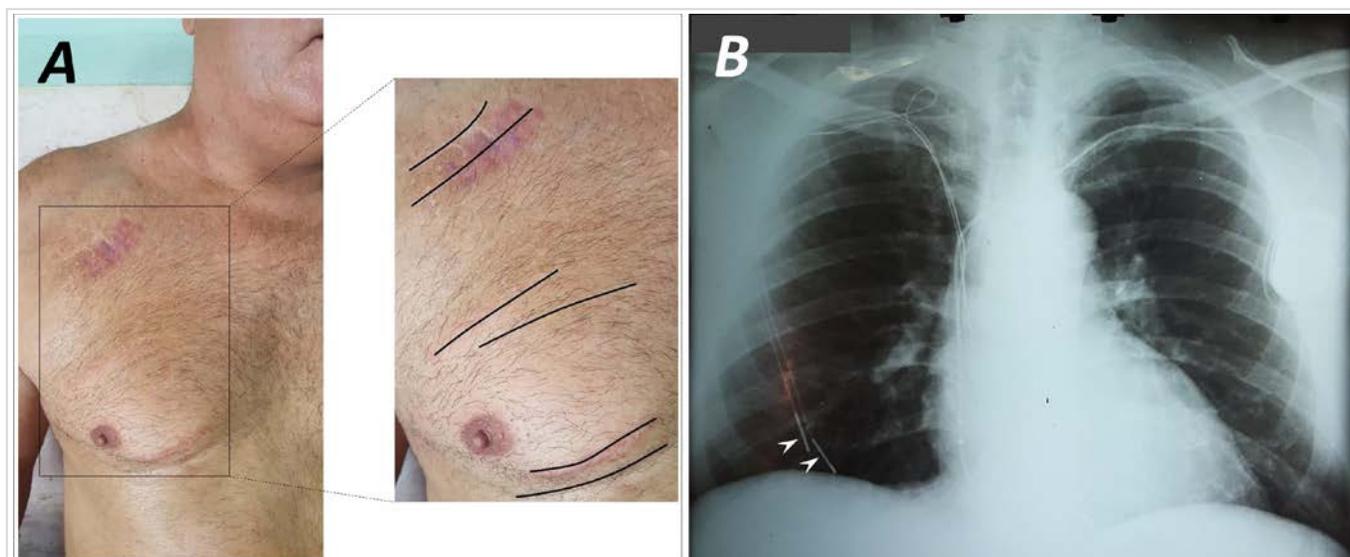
A. Surgical wounds of previous attempts of removing abandoned electrodes. The site chosen for the most recent incision, through which the electrode leads were extracted (second from top to bottom) coincided with a previous wound at the same location. The lines mark the surgical scars. B. Simple chest radiography, where are observed the abandoned electrodes in the right hemithorax projection, with end connectors (arrowheads) presumably at the level of the hemidiaphragm of that side.
